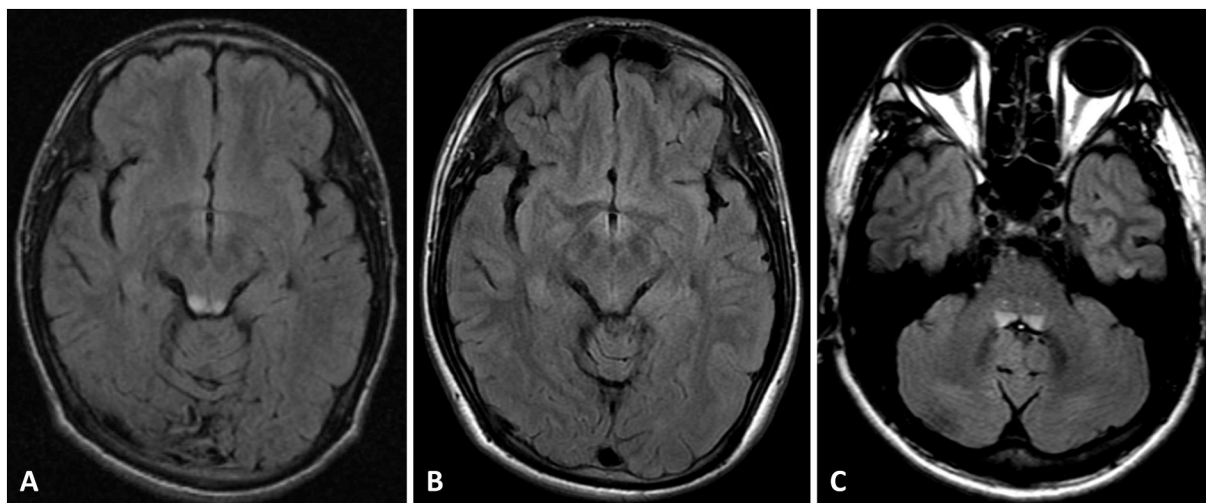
Brain MRI: (A) 19-year-old fluid attenuation inversion recovery (FLAIR) image showing bilateral hyperintensities of the inferior colliculus; (B) 21-year-old FLAIR image showing disappearance of the previous lesions of the inferior colliculus; (C) 24-year-old FLAIR image showing bilateral and symmetrical hyperintensities of vestibular nuclei.
